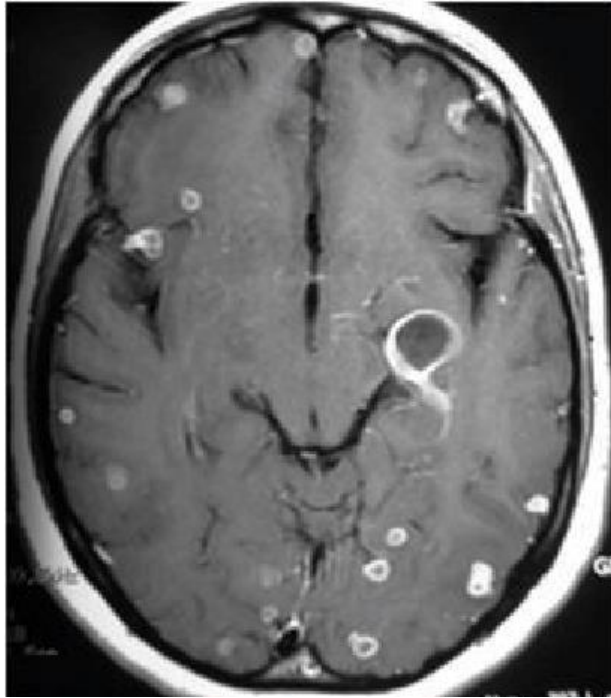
MRI of a disseminated central nervous system TB infection ⁷⁵.
